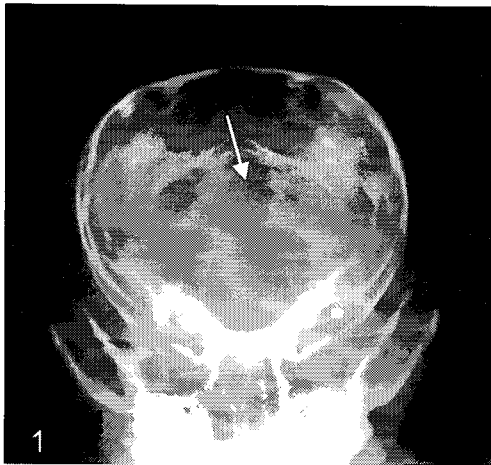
Rostradorsal-caudoventral oblique radiograph of the skull. Note the dorsal extent appearance of the foramen magnum (arrow). Severe occipital dysplasia.
